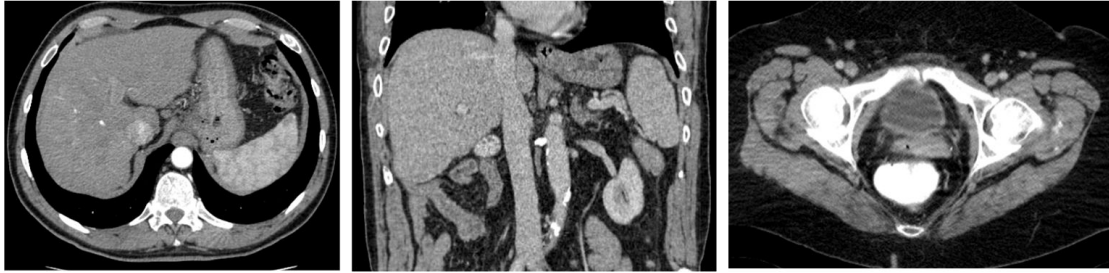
Left and middle: arterial contrast phase CT scans of the liver. The liver parenchyma shows a weak contrast to neighboring structures such as muscles or the stomach. Right: CT scan of the bladder.
